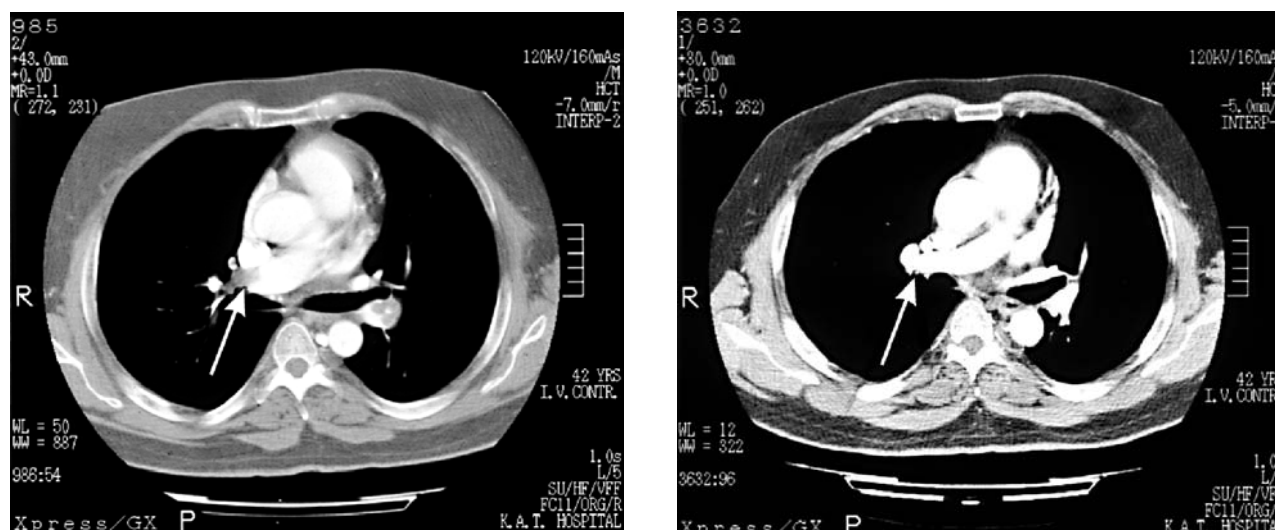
Computed tomography of the chest on admission (left) and after thrombolysis (right).
